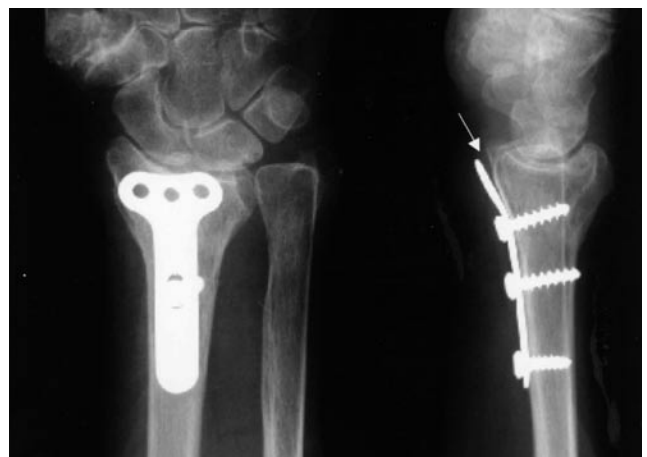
Anteroposterior (left) and lateral (right) x-rays of volar buttress plate over distal radius. Arrow (right) points to gap between plate and volar cortex.
